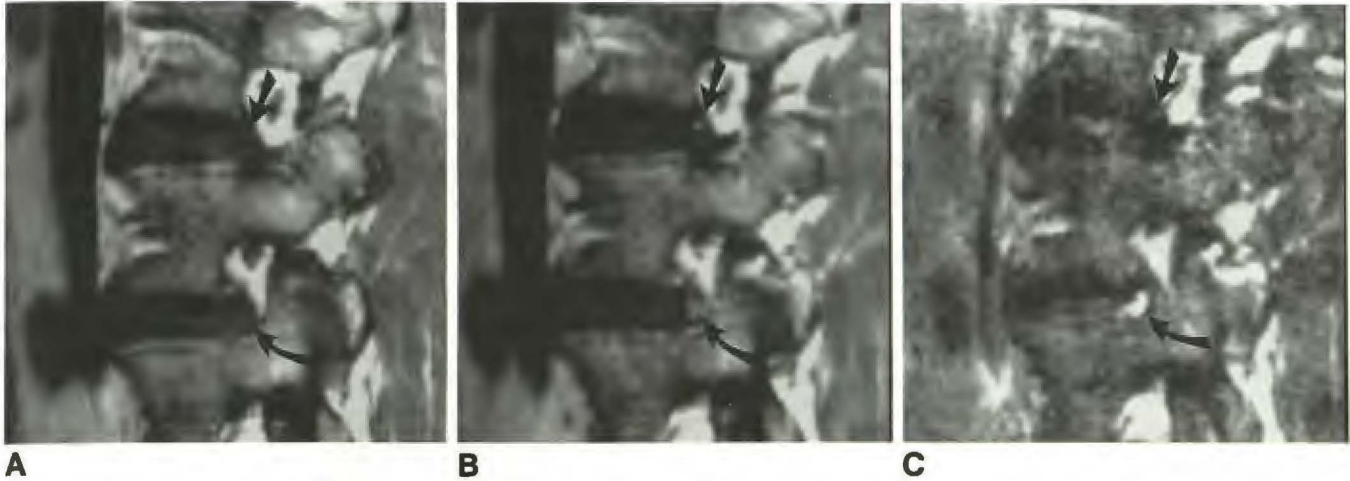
A–C, Types II and III anular tears on T1-weighted parasagittal images before (A) and after (B) contrast and on T2-weighted image (C). Type III tear (straight arrows) is seen at L3–L4 level as small linear area of enhancement adjacent to inferior L3 endplate on T1-weighted images (A and B) and as small linear area of increased signal on T2-weighted image (C). Type II tear (curved arrows) is seen at L4–L5 level as a more globular area of enhancement within central portion of peripheral annulus on T1-weighted images (A and B) and as increased signal on T2-weighted image (C).
